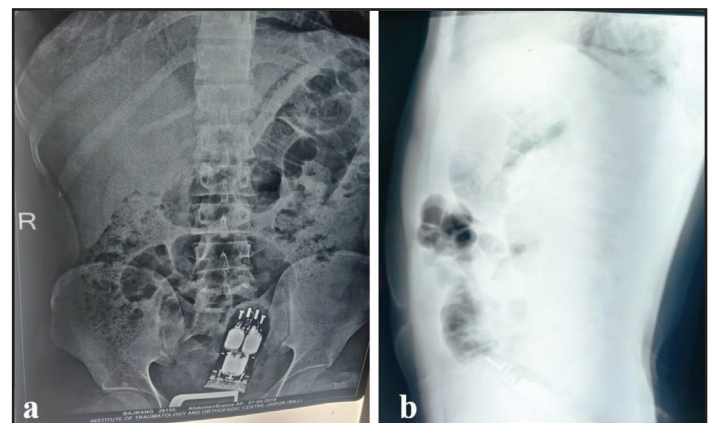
X-Ray abdomen (a) postero-anterior and (b) lateral view showing the presence of a foreign body in the rectum.
